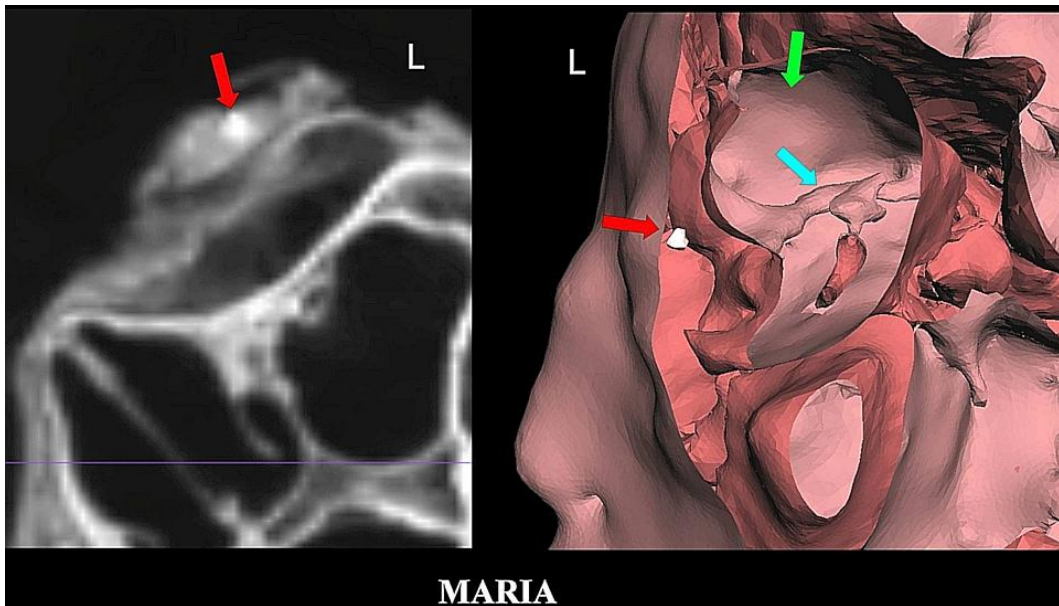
2D coronal CT scan (*left*) and sagittal cut section of 3D CT (*right*) showing presence of calcification or metallic foreign body (*red arrow*) in left upper eyelid. The hyaloid canal (*blue arrow*) inside the large sized partially collapsed left eyeball can also be identified (*green arrow*).
